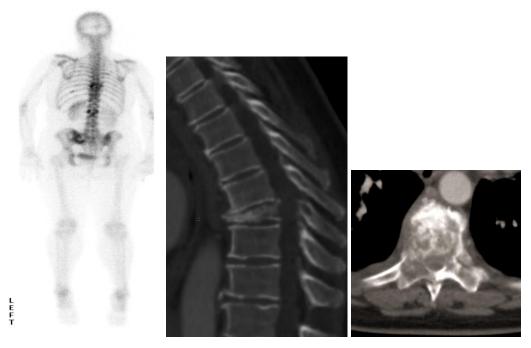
Bone scan, CT same patient demonstrating the degree of bone destruction, remnant bone stock and canal narrowing by the tumor/retropulsed bone.
